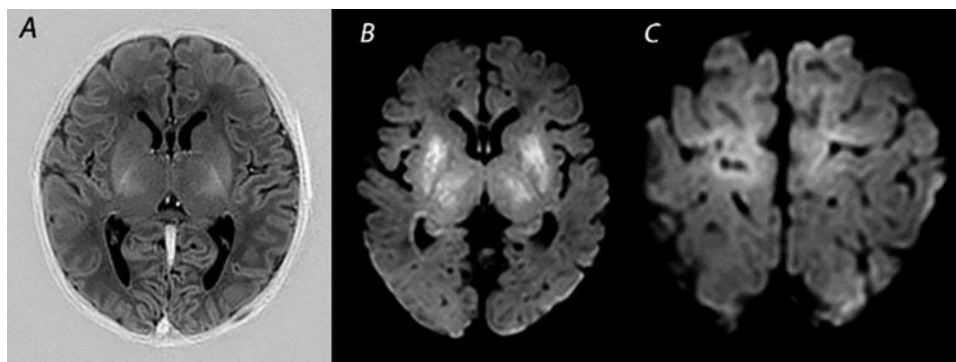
MRI performed on a 5-day-old infant with Apgar scores 0/2/5. Infant received therapeutic hypothermia for HIE injury. Upon MRI imaging, the signal intensity of the posterior limb of the internal capsule appeared normal on T1-weighted imaging (A). Diffusion-Weighted Imaging (DWI), however, indicates extensive diffusion restriction within the basal ganglia, thalami (B) and the perirolandic cortex (C). Despite redirection of care, the infant died [15].
